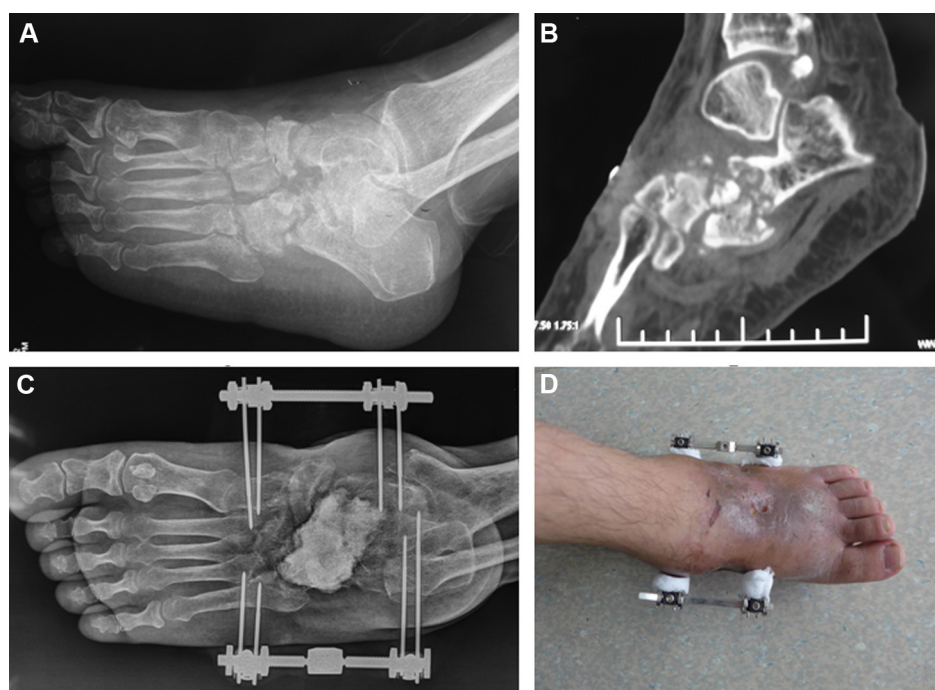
A 34-year-old man was diagnosed TB in left midfoot. A. Plain film showed destruction in Chopart joint and TMT joints, as well as osteoporosis in whole foot. B. CT showed destruction in calcaneocuboid joint. C. After first operation, two mini external fixators were used at both sides to maintain the length of foot. Bone cement was used to fill into the bone deflection. D. The appearance of left foot after first operation.
